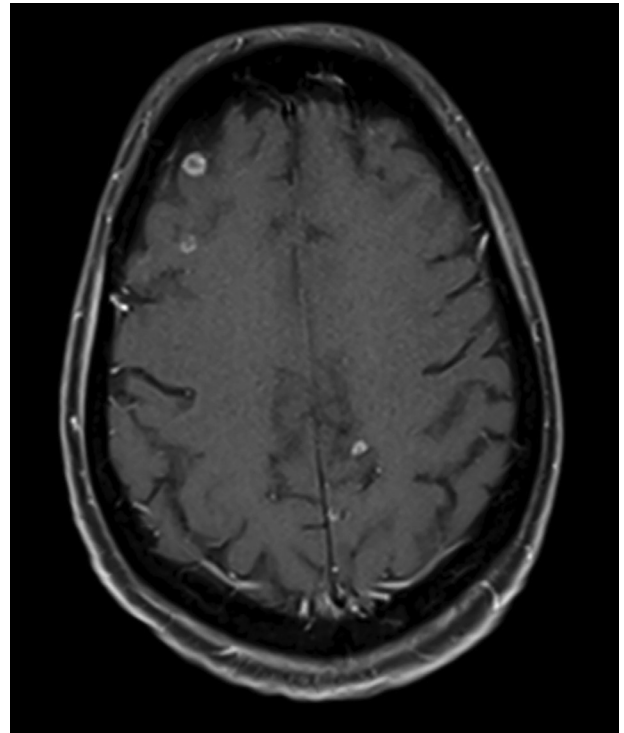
Post-contrast axial T1-weighted brain magnetic resonance imaging shows contrast-enhancing metastatic lesions in both cerebral hemispheres
